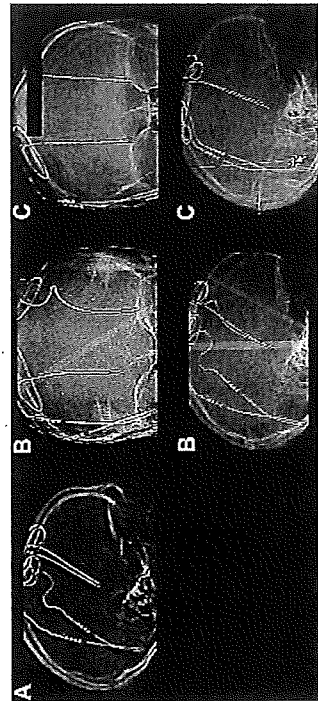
Ventral lead migration shown by serial x-rays. A) A skull x-ray at one month post-implantation. B) A skull x-ray at fourteen months following first operation. The left and right leads had moved approximately 16 mm and 5 mm downwards from the initial position, respectively. C) A skull x-ray at one month following lead replacement.
